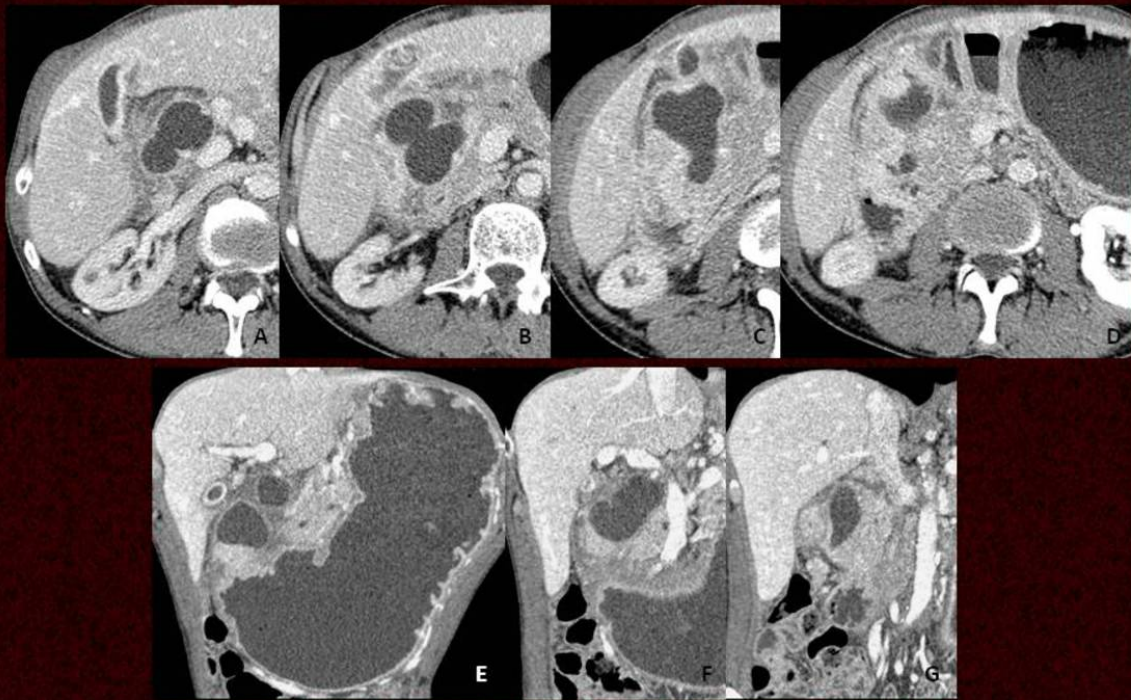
Pancreatic pseudocyst in a 57-year-old male patient presenting with abdominal pain and vomiting. Axial (A-D) and coronal reformatted (E-G) images from the CT scan performed after IV administration of contrast material show a cystic lesion involving the pylorus / duodenal bulb, with consequent gastric dilatation. Cyst fluid analysis was consistent with a pseudocyst.
